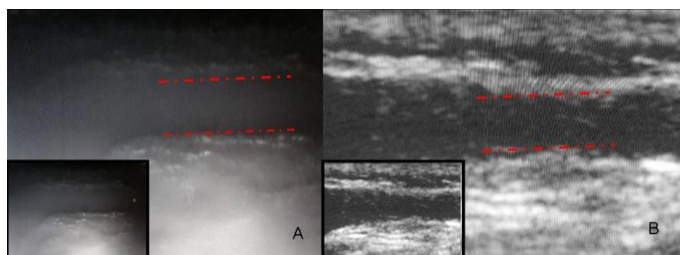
A: Small frame: The ultrasonographic visualization of arteriovenous (AV) fistula vein graft which was created using the endothelium protection solution, Big frame: The dashed red line shows the regularity of endothelial wall. B: Small frame: The ultrasonographic visualization of AV fistula vein graft which was transplanted without using an endothelium protection solution, Big frame: The dashed red line shows the irregularity of endothelial wall.
